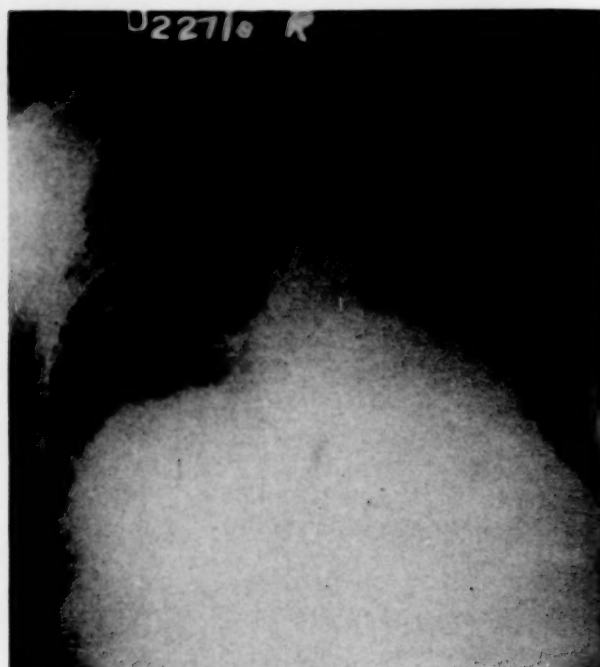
X-ray taken shortly before the patient's death, Case iv.
